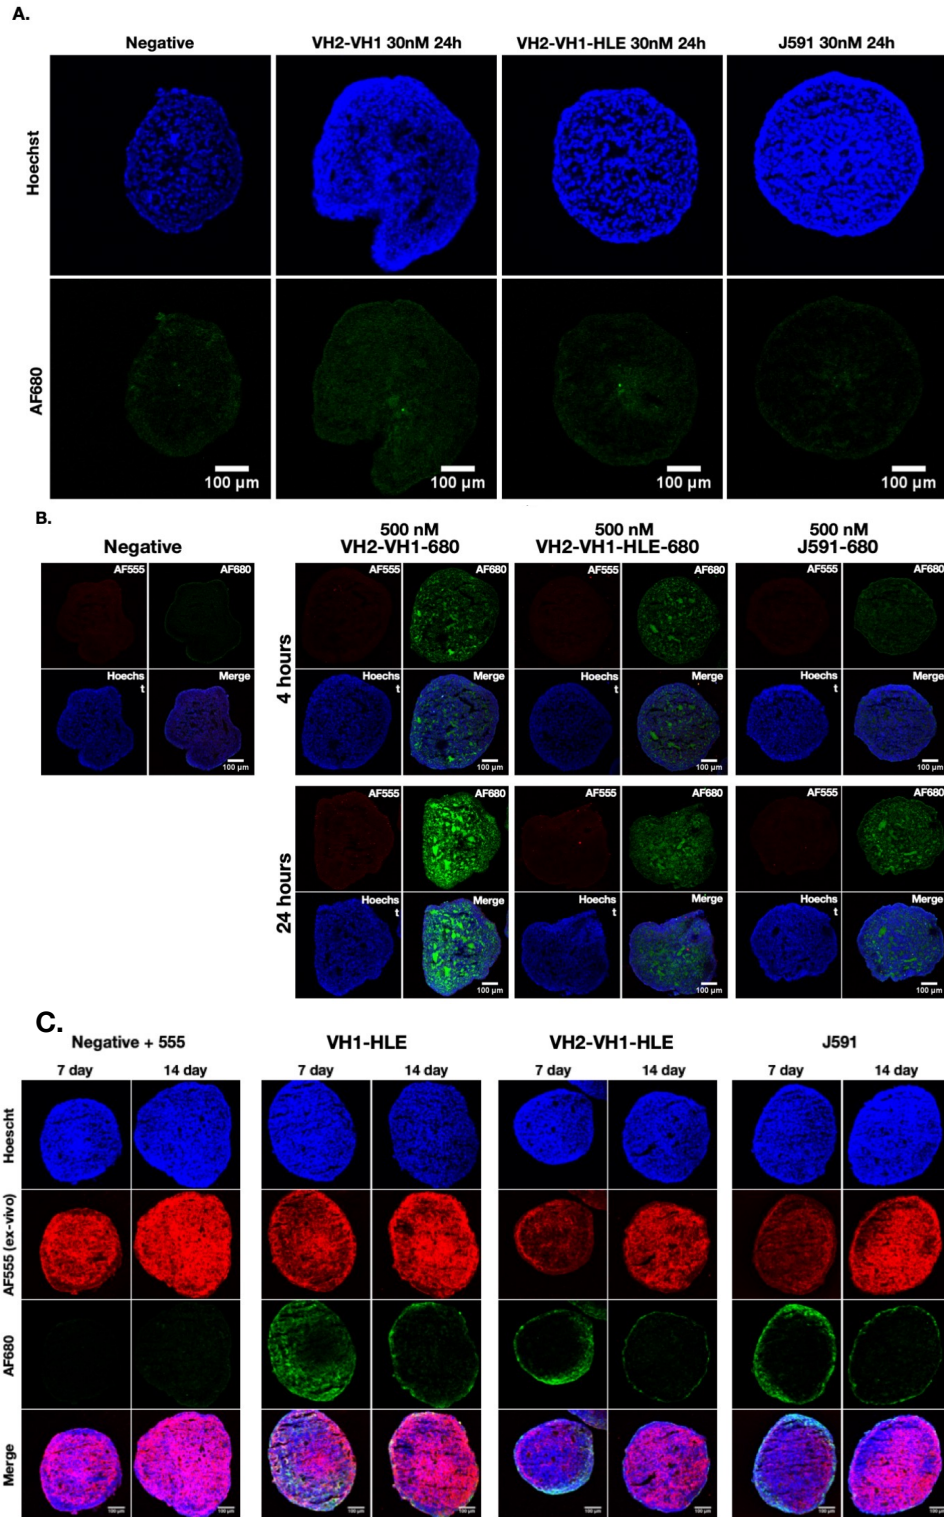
PSMA-negative DU145 spheroids display homogenous distribution.
